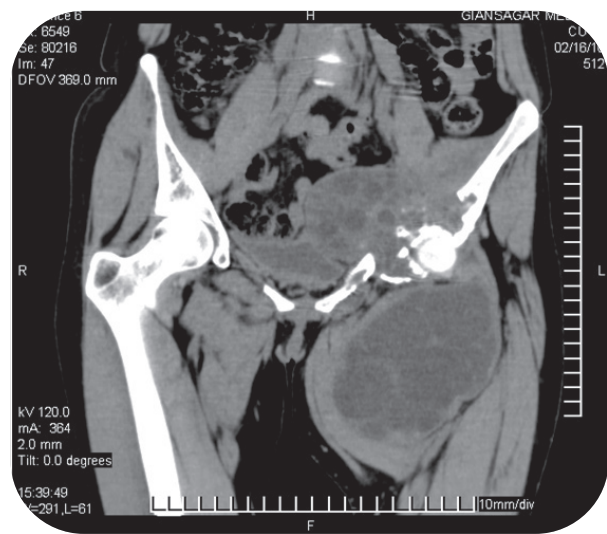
Coronal reformatted plain CT scan of pelvis and thighs showing huge multi-septated cystic mass involving various medial muscles of thigh showing unusual extension into pelvis on left side with associated destruction of left hemipelvis.
